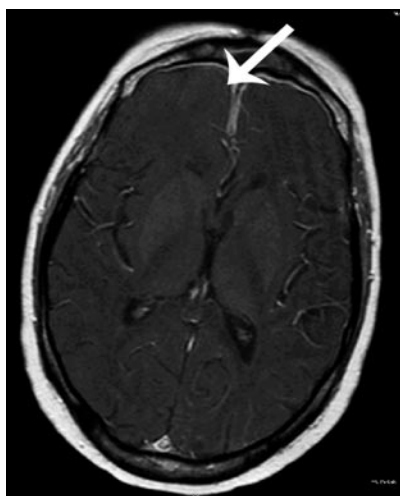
Patient with WG and severe frontal cephalgia due to pachymeningitis and orbital granulomata with penetration from the sinus ethmoidales. T1-weighted MRI with gadolinium appears to be the most sensitive but not highly specific method for detecting thickening and enhancement of the meninges.
